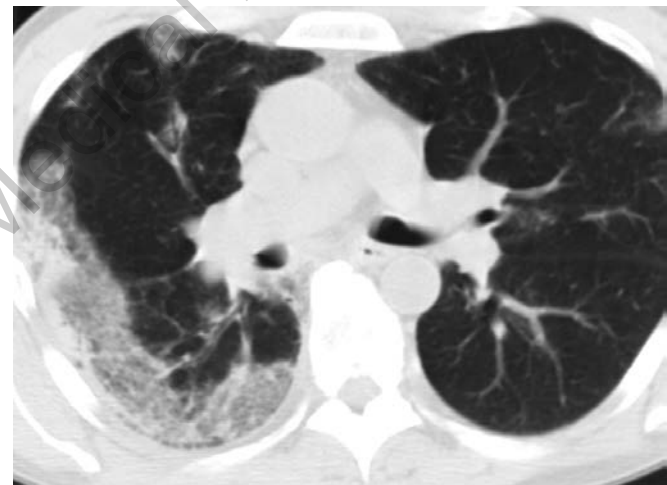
CT chest in a patient with chronic eosinophilic pneumonitis with peripherally distributed opacities
